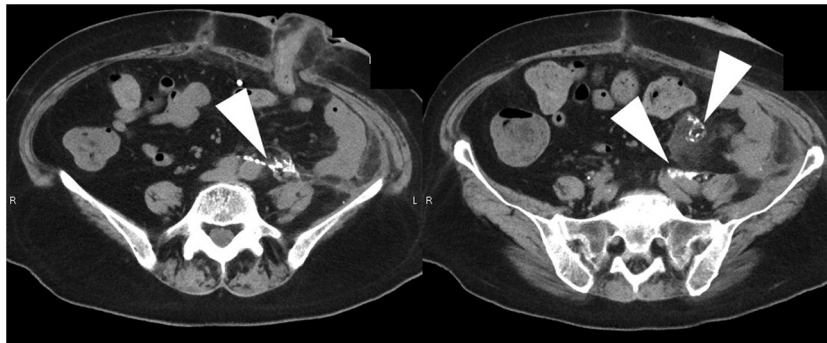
Postoperative CT shows residual barium in the intraperitoneal and retroperitoneal cavities (arrowheads).
